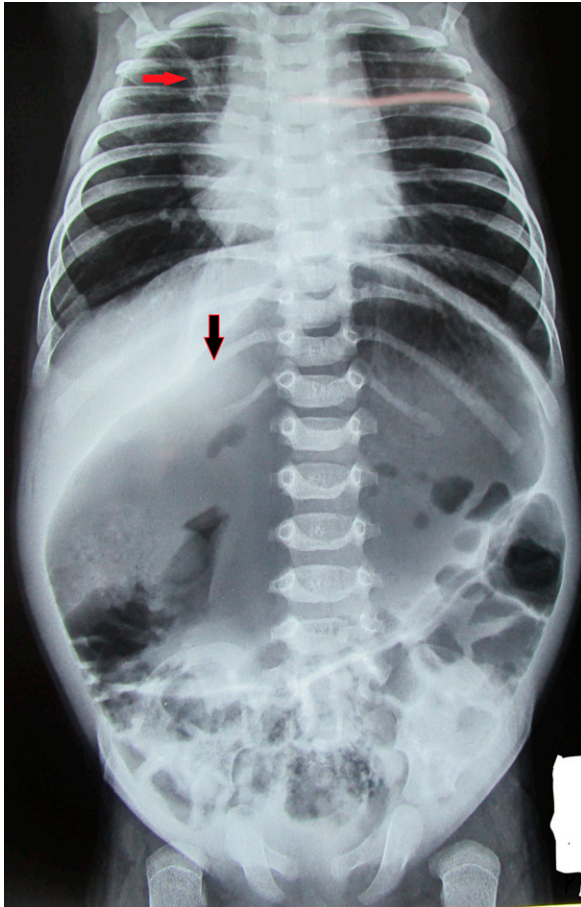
Radiograph of the chest and abdomen showing right upper lobe consolidation (red arrow) with a hugely dilated stomach (black arrow).
